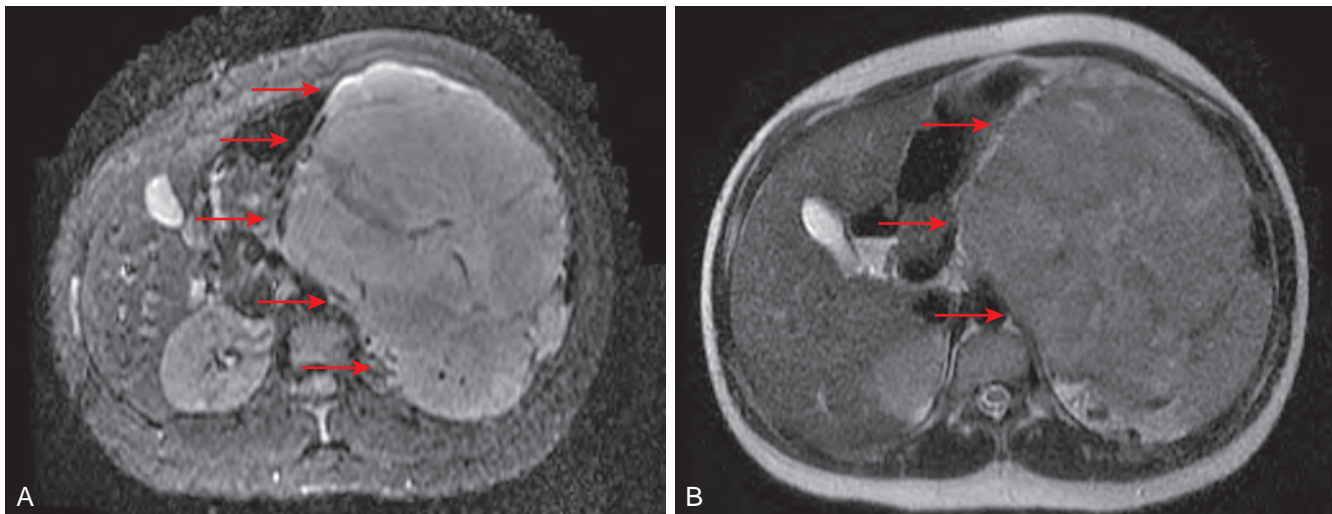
A 65-year-old woman with left side heterogeneous enhancing suprarenal lesion (adrenal cortical carcinoma) with select images from a 1.5-tesla abdominal magnetic resonance image. A, Moderately weighted T2 STIR (short-tau inversion recovery) images with a hyperintense signal (red arrows). B, Heavily weighted T2 single-shot, fast spin echo isointense signal. These findings are all dependent on the degree of T2 weighting.
